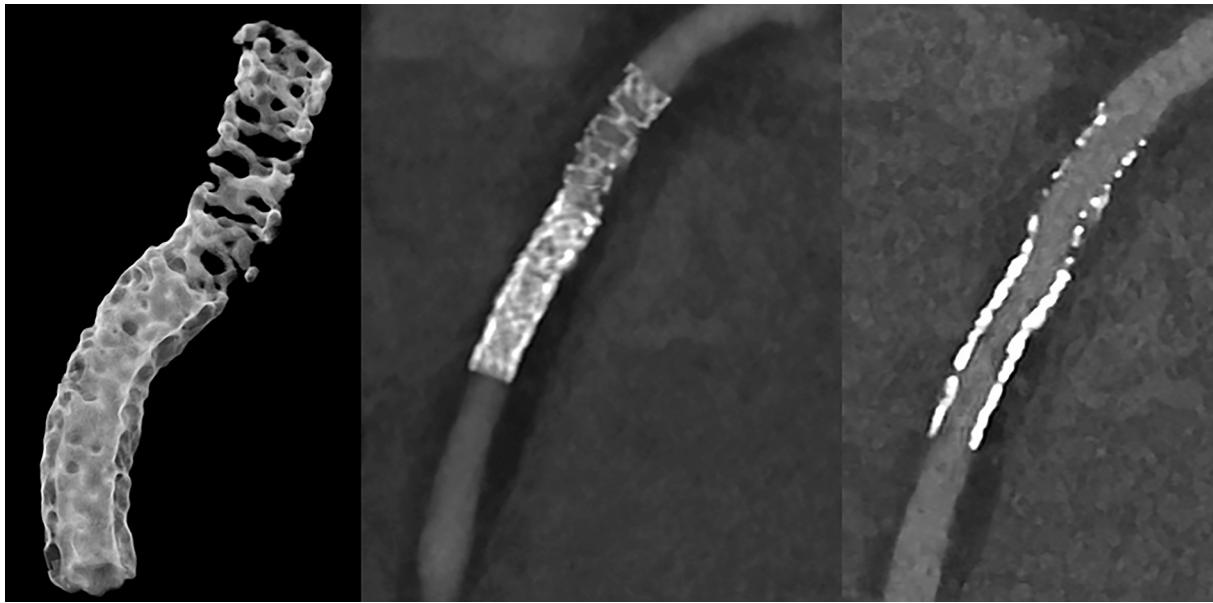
Representative case of overlapping coronary stent segments assessed with ultrahigh-resolution photon-counting CT. Representative case of a 52-year-old male with effort angina who underwent UHR PCD-CT (Bv56) for the exclusion of ISR following RCA PCI (3.5 mm) and re-PCI using DES (3.5 mm) due to in-stent restenosis. Ultrahigh-resolution PCD-CT ruled out relevant ISR despite overlapping stent segments and provided clear visualization of the stent structure. Abbreviations: PCD-CT: Photon-counting Detector Computed Tomography; PCI: Percutaneous Coronary Intervention; RCA: Right Coronary Artery; UHR: Ultrahigh-resolution.
